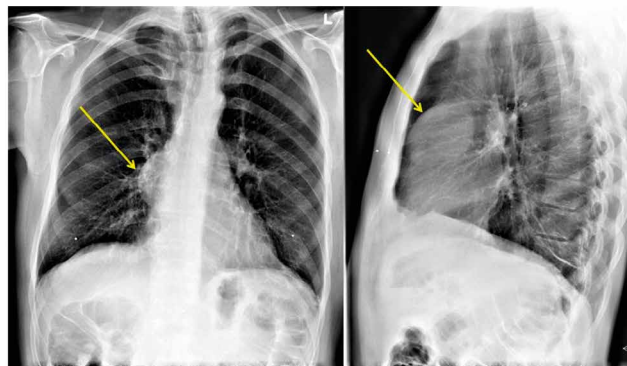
Chest X-ray shows a bulging mediastinal mass (arrows) at the right hilum adjacent to the right atrium in a patient with myasthenia gravis
